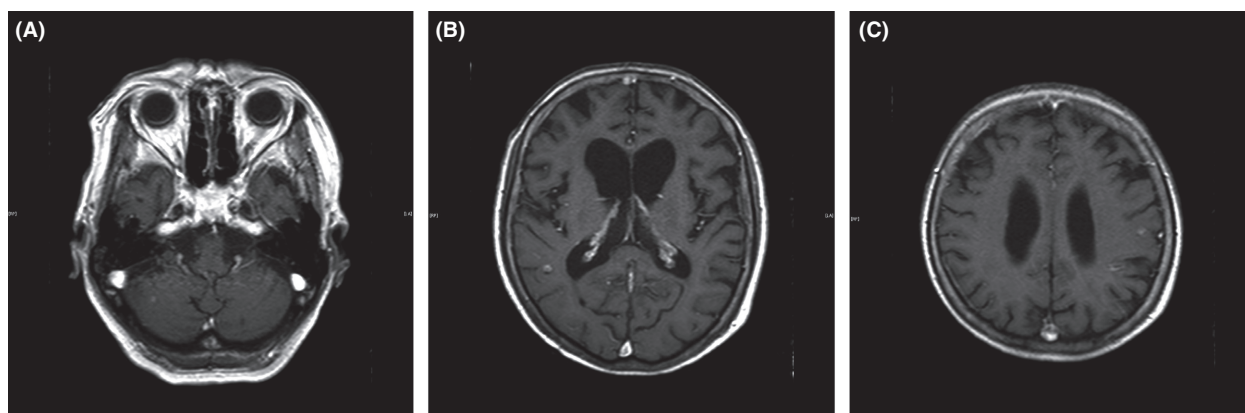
Enhanced brain magnetic resonance imaging (MRI) images taken before withdrawal of crizotinib. A shows a newly appeared dissemination on the right cerebellar surface. B and C show pre-existing cerebral tumors in the right and left temporal lobes, respectively.
